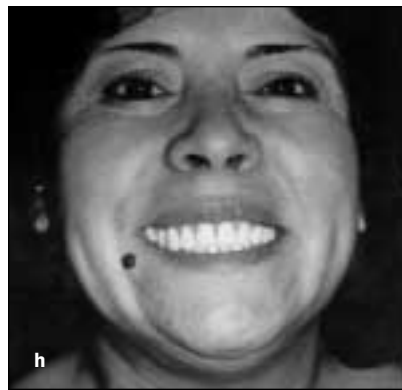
Patient C. The patient is a woman 34 years 3 months of age. (a) Initial facial photograph. Note the anterior open bite. (b) Initial radiograph, which demonstrates the anterior open bite with skeletal hyperdivergency. (c) Initial intraoral photograph. (d) Close-up of the initial facial photograph, which shows an unconscious anterior tongue rest posture. (e) Initial facial profile photograph, which demonstrates lip protrusion. (f) Radiograph taken immediately before debonding when patient was 38 years 5 months of age. The anterior open bite has closed after 22 months of spur appliance wear. (g to i) Photographs taken when patient was 45 years 10 months of age, 7 years posttreatment. Note the stability of the corrected anterior open bite, the pleasing upper-lip smile line, and the improved facial profile. (j) Radiograph taken when patient was 45 years 10 months of age. Note the positive overbite with incisal contact. (k) Superimposition of radiographic tracings when patient was 34 years 3 months of age, 38 years 5 months of age, and 45 years 10 months of age.
